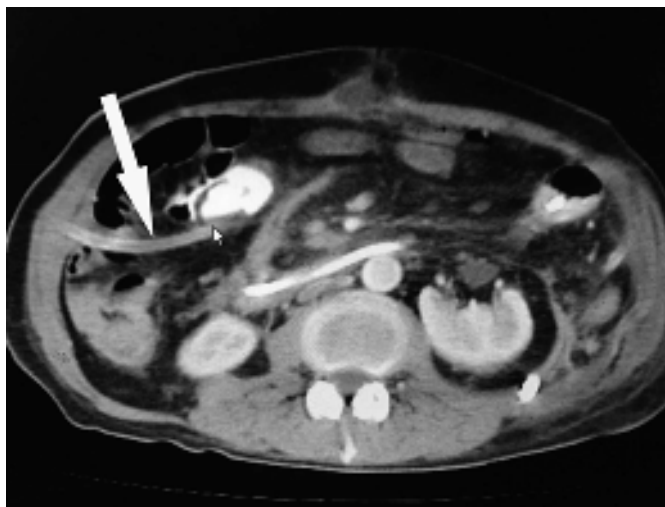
Abdominal CT scan showing the catheter placed after a laparotomy with necrosectomy and drainage of the cavity for infected pancreatic necrosis (white arrow indicates the surgically placed drainage catheter)
